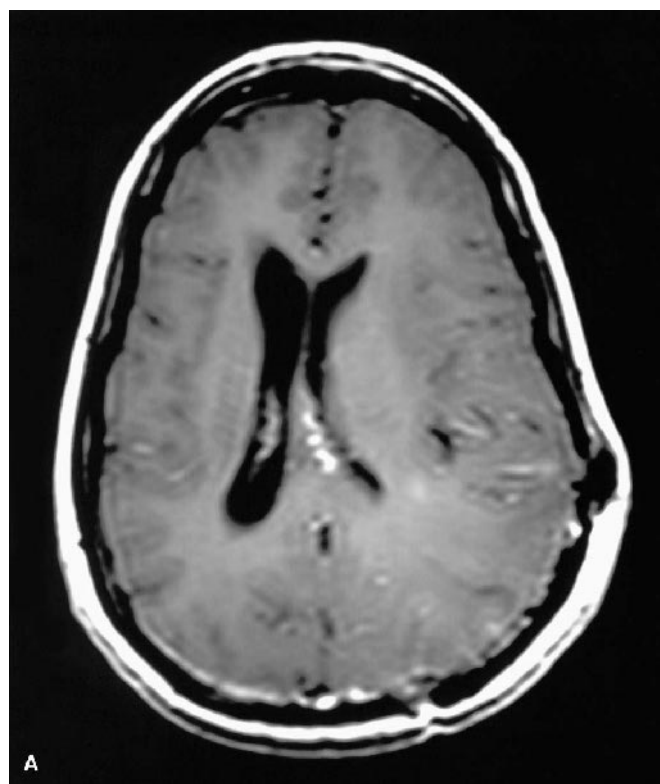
Meningeal thickening: Conventional (A) 2DFT T1-weighted (TR/TE = 500/8 milliseconds) and (B) d CUTE (TR/TE = 500/0.08 minus 5.95 milliseconds) images. Normal meninges are well seen in (B). There is thickening at the site of a previous craniotomy (arrows).
